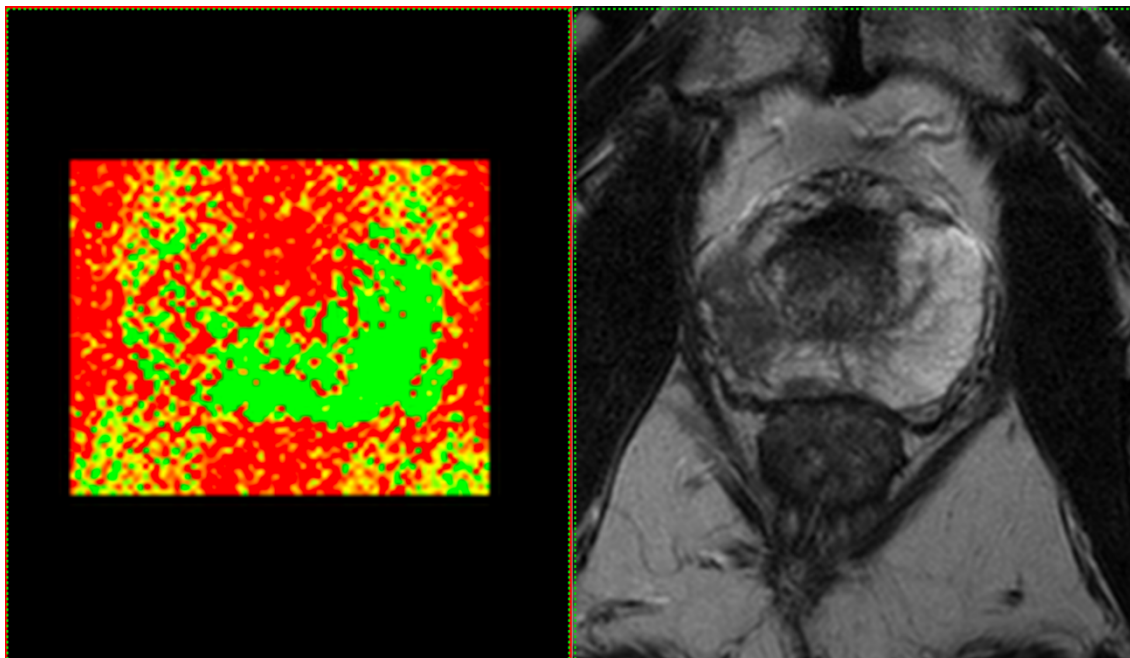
Indetermined findings on LI-map. Inhomogeneous SI of the right PZ on LI-map (left image) with interspersed (predominantly) red-yellow areas on a green background. The lesion was judged equivocal (PI-RADS 3) also on biparametric MRI (right image: axial T2W).
